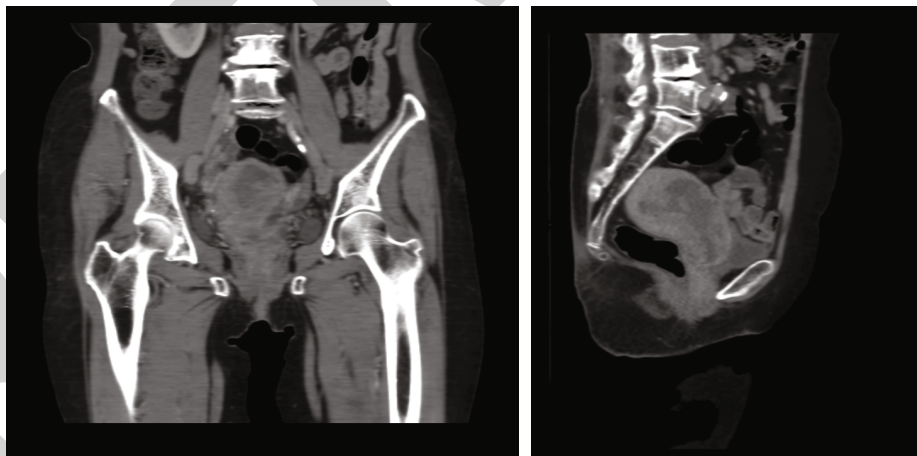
MRI image of the abdomen. There are soft tissue density tumors in the uterine cavity; the density of which is lower than that of the strengthened normal uterine muscle. The tumor is cauliflower-like or nodular, and the surrounding can be surrounded by lower-density intrauterine effusion. When the tumor invades the muscle layer, it strengthens. The normal uterine muscle has limited or diffuse low density, thinning of the muscle layer, and tumor invasion often manifests as blurred uterine edges or soft tissue strips or nodules.
